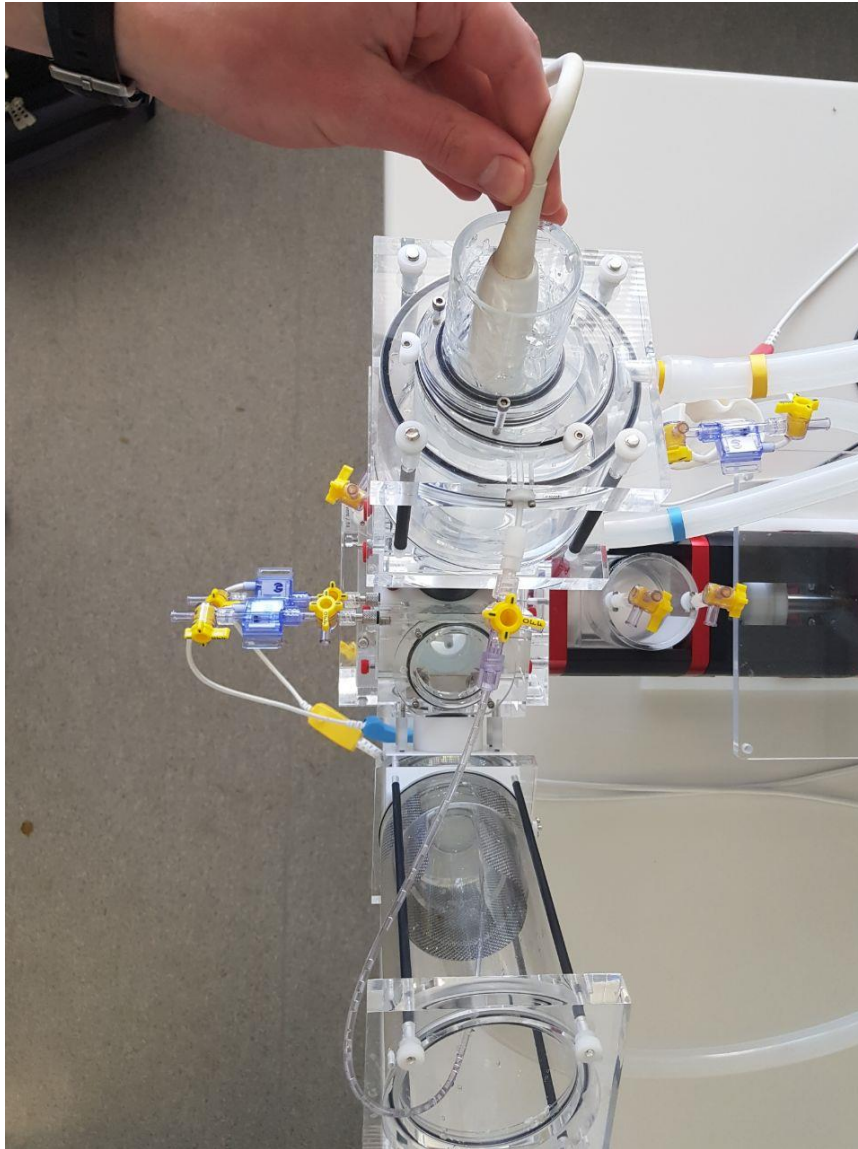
Echocardiography performed during pulse duplication
